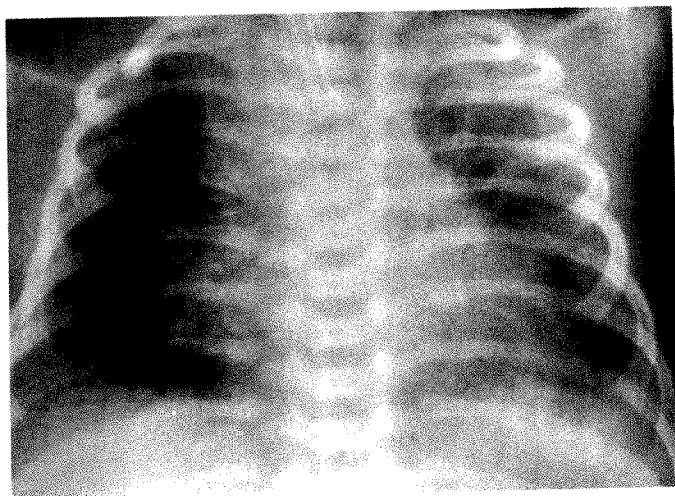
Chest radiograph shows selective clearing of severe respiratory distress syndrome in right middle and lower lobes 4 hr after surfactant treatment.
